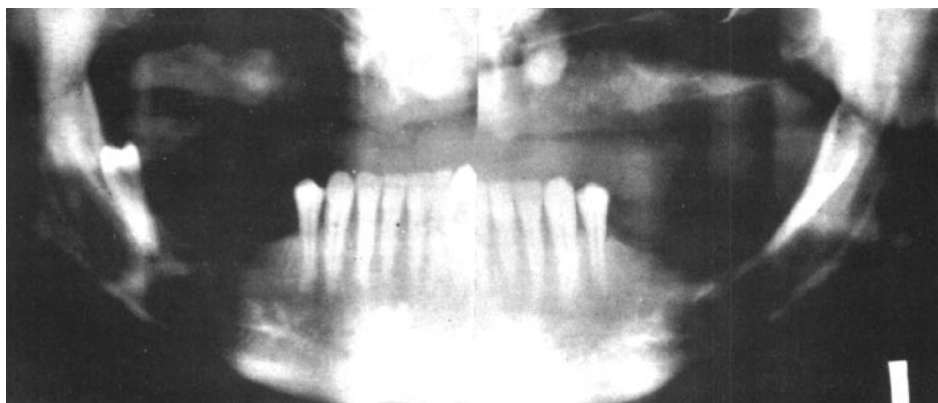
Panoramic radiograph showing extreme distal migration of lower right second bicuspid. All three molars are missing.
